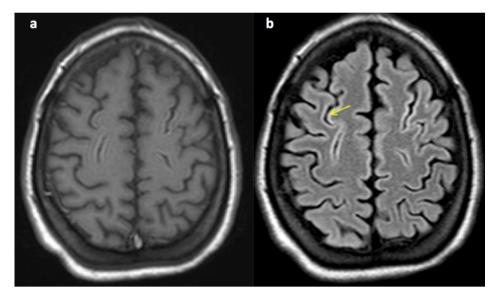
T1W (a) and FLAIR (b) images, 1.5 months after the insult, show laminar necrosis in the bilateral superior frontal gyri and insula.
